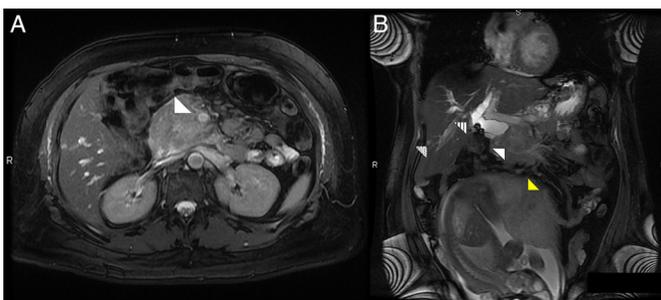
T2-Weighted abdominal magnetic resonance imaging from presentation at 30 weeks. (A) Axial view showing pancreatic head mass (arrow). (B) Coronal view showing gravid uterus (yellow arrow), pancreatic head mass (white arrow), significantly increased dilatation of the CBD (striped arrow), and an incompletely characterized hyperintense liver lesion (dotted arrow) concerning for metastasis.
